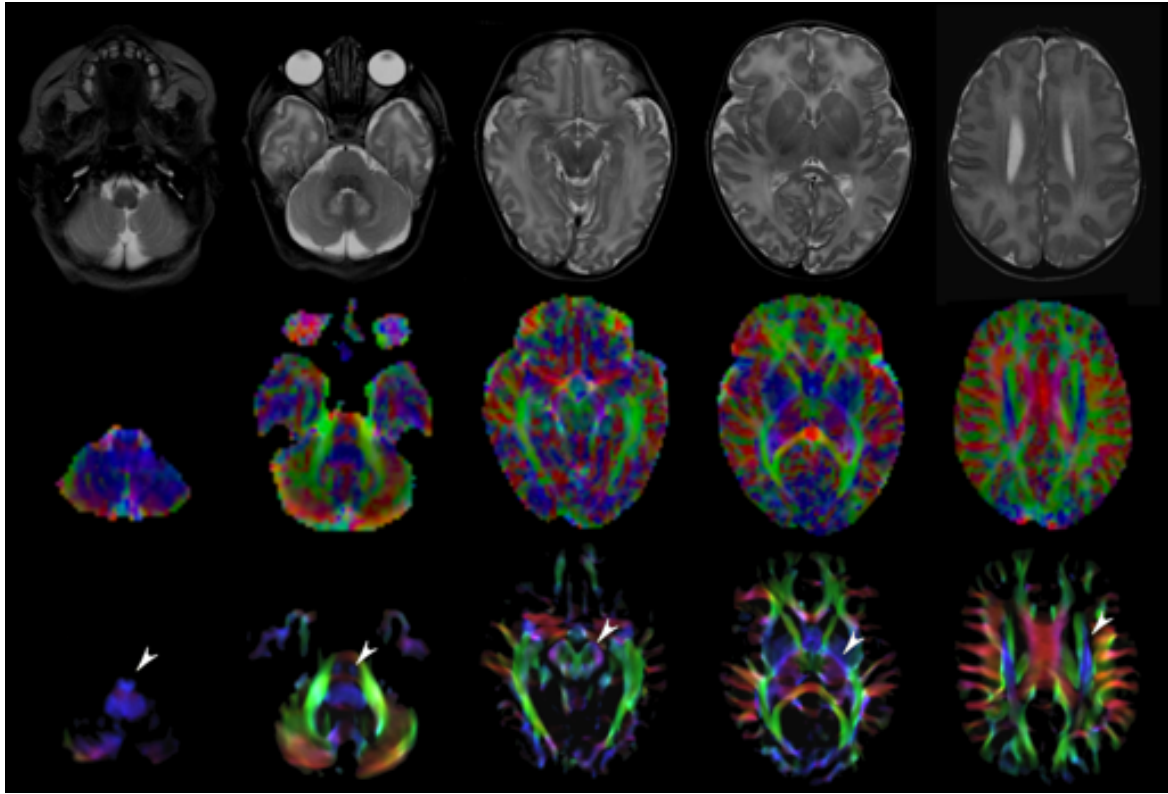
EV maps and stDEC-TDI maps at 5 canonical brain levels (rostral medulla, middle pons, rostral midbrain, internal capsules, corpus callosum) in a 6-day neonate. Axial T2-weighted images (upper row) and corresponding EV maps (middle row) and stDEC-TDI images (bottom row). Conventional color scheme: blue (inferior-superior), green (antero-posterior), and red (left-right). Note that even in an unmyelinated brain the corticospinal tract is clearly visible from the bulbar level to the centrum semiovale in the stDEC-TDI map (arrowheads), while it is more difficult to distinguish in the EV maps especially at the bulbar level (first column).
